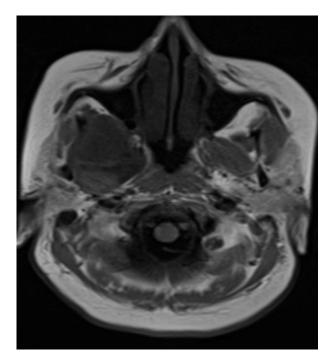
(On left) Axial T1W MRI shows T1 hypo to isointense, Image 1B (On right) Axial T2W shows iso to hyperintense mixed solid cystic mass centered in the right masticator space
